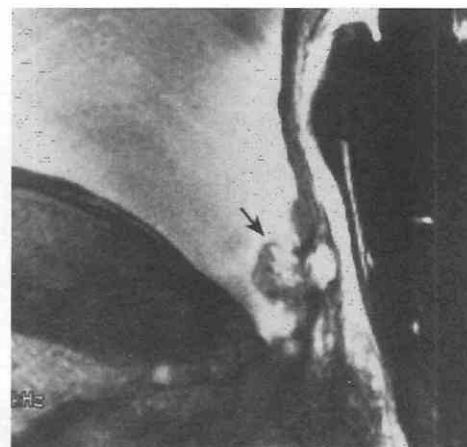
Endorectal coil evaluation of a patient after prostatectomy. Sagittal midline, T2-weighted, fast spin-echo image (TR = 4000 msec, TE_{eff} = 140 msec) shows the bladder wall as a low-signal-intensity structure. The wide bladder neck down to the membranous urethra represents the appearance after prostatectomy. In this patient with a rising prostate-specific antigen level, a large nodule was found at the anastomotic site (arrow). Its appearance suggested recurrent tumor; at surgery, however, the diagnosis was recurrent benign prostatic hyperplasia. TE_{eff}, effective echo time.
